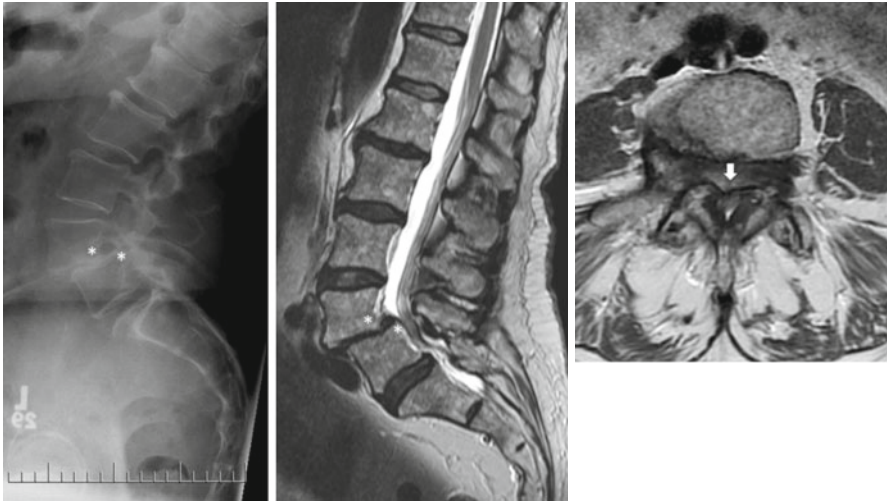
Lateral standing radiograph, midsagittal MRI, and axial MRI at L4–L5 in a 71-year-old female with a degenerative spondylolisthesis at L4–L5 and associated back pain and neurogenic claudication with less than one-block walking tolerance. As marked by the *white asterisks*, the L4 vertebra has slipped forward on the L5 vertebra. In combination with the facet joint OA, this causes severe spinal stenosis to the point where the spinal fluid is no longer seen (*white arrow*) compared to the degree of stenosis demonstrated in Fig. 4.1. This particular patient has a high pelvic incidence (74° ; normal is approximately $50 \pm 10^\circ$) which gives her higher than normal lordosis, which increases the loading of the facet joints and decreases the load on the disc. Complete disc collapse is seen at the L4–L5 level, with relative normal discs above and below
